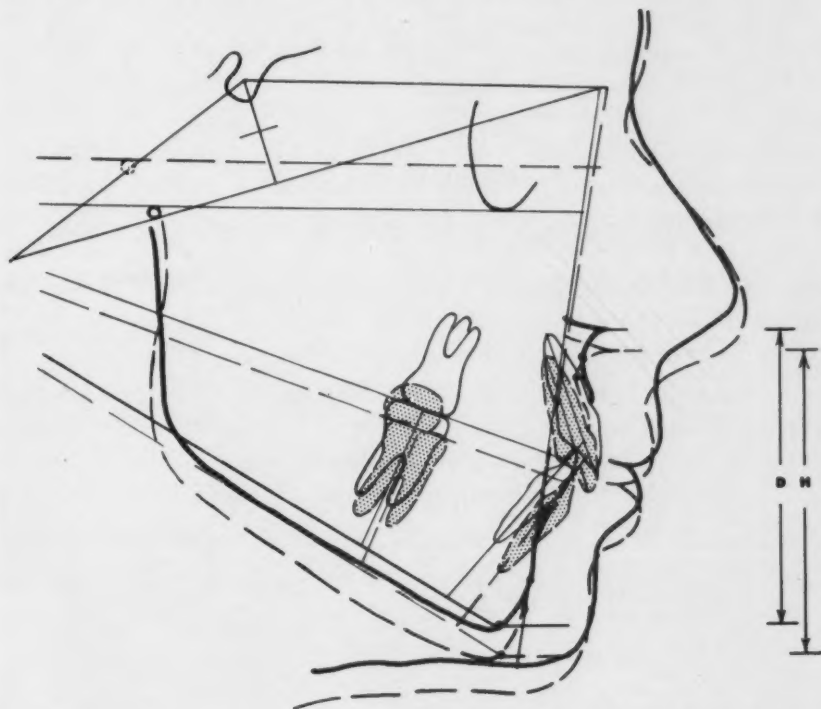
Case 4, Patient D. S. Superposed tracings of cephalometric roentgenograms. Solid line, November, 1951; broken line, July, 1954.
